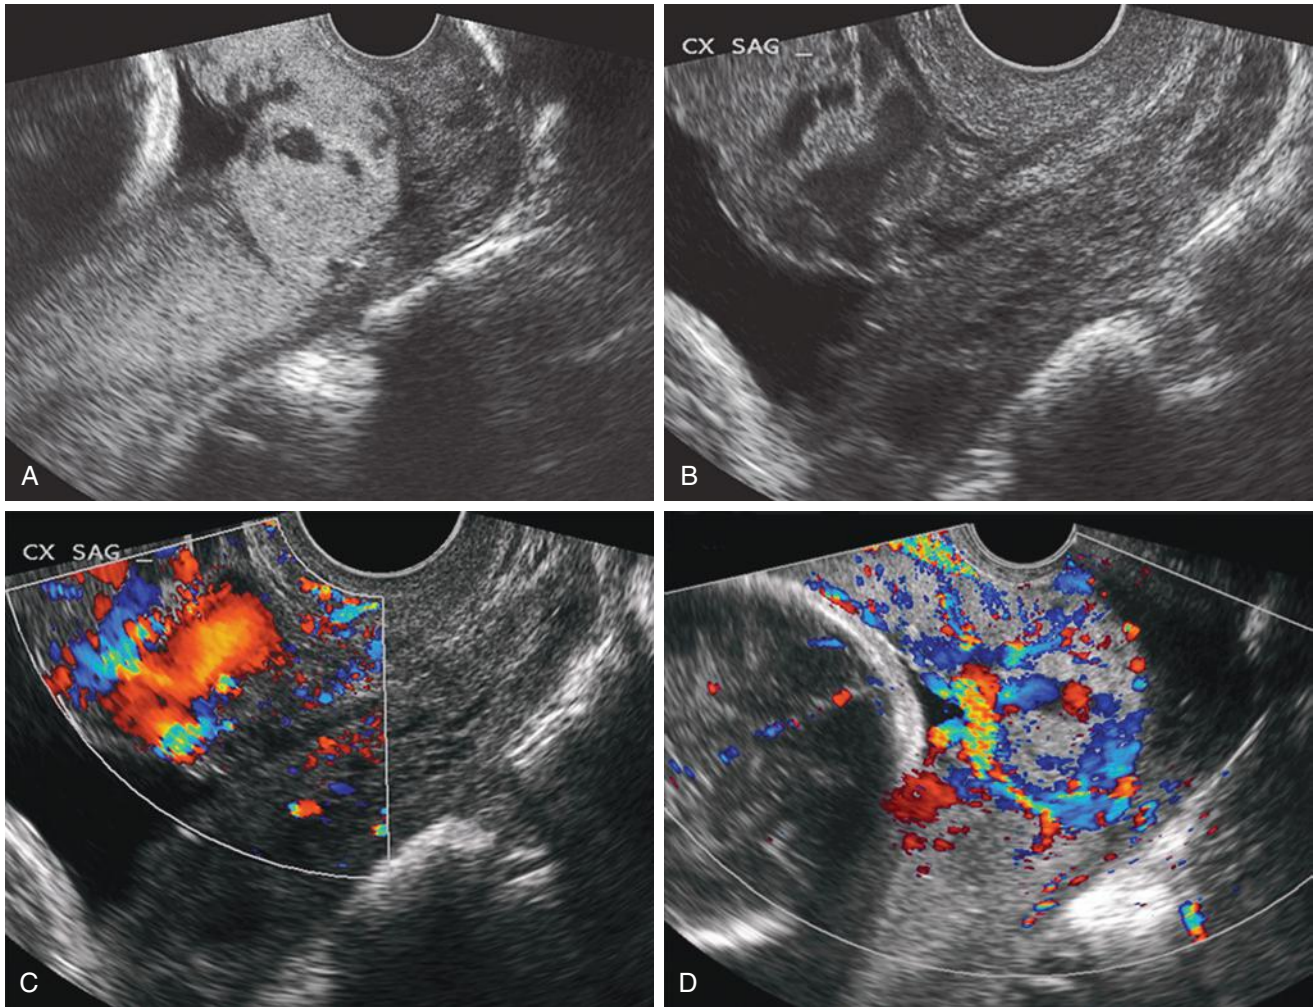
Placental lacunae. A and B, Transvaginal images in the sagittal plane depict placenta previa with multiple placental lacunae. The images are from two different pregnancies, each at 28 weeks of gestation. C and D, Color Doppler ultrasound imaging (from the patients shown in A and B, respectively) demonstrates turbulent flow within these irregularly shaped vascular spaces.
